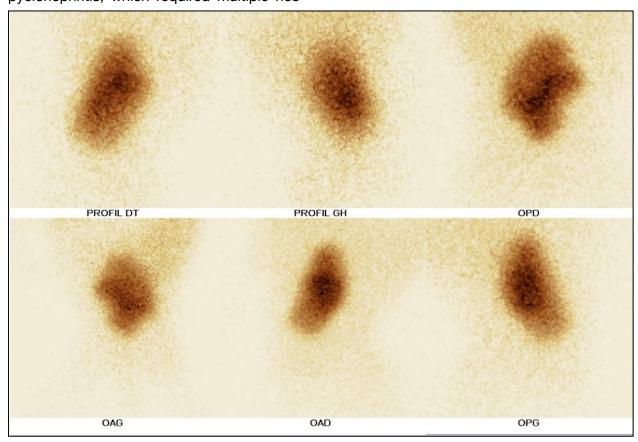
Different views of 99mTc-DMSA renal scintigraphy
